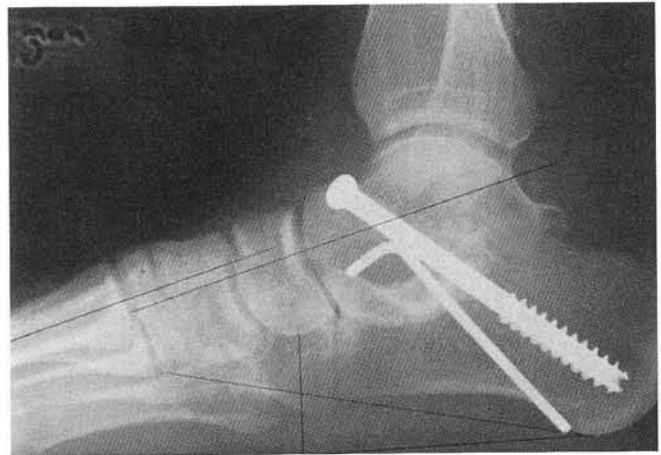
Lateral view, long-term follow-up weight-bearing radiograph.
